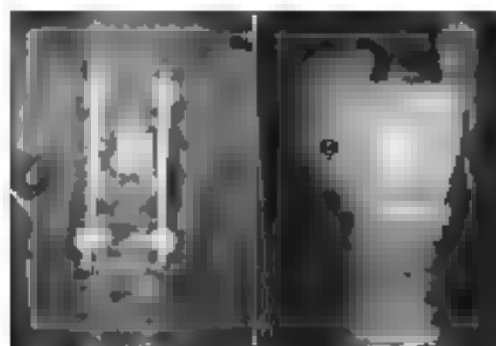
Post-operative x-rays, after anterior surgery, AP and Lateral view showing anterior reconstruction with a distractible cage.
